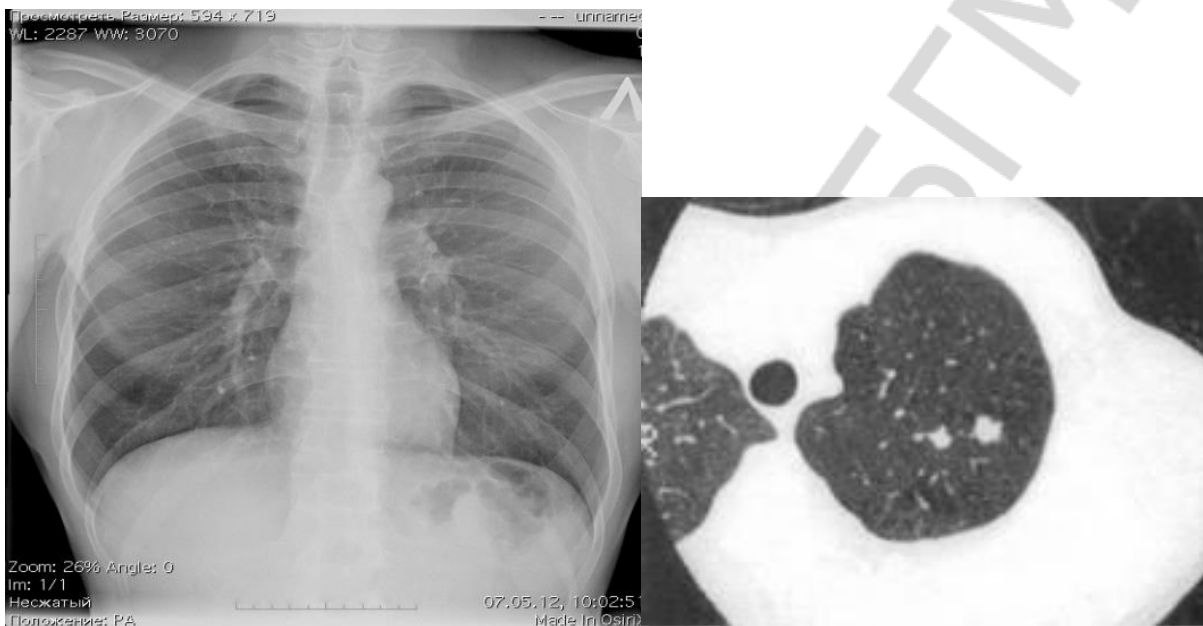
Survey X-ray and CT of patient A.
